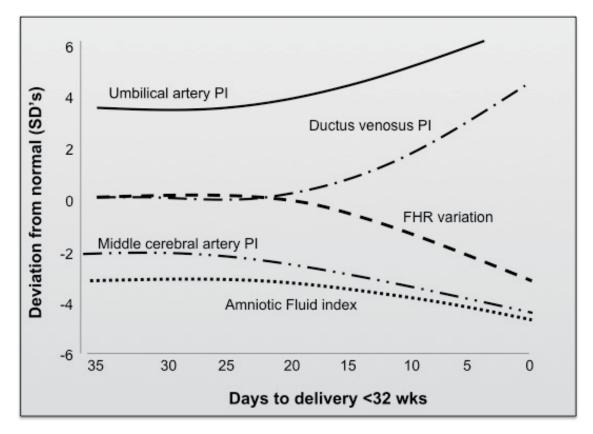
Sequence of changes of the umbilical artery, middle cerebral artery and ductus venosus Doppler, amniotic fluid index and fetal heart rate in growth restricted fetuses delivered before 32 weeks. Hecher *et al.*, 2001b.
